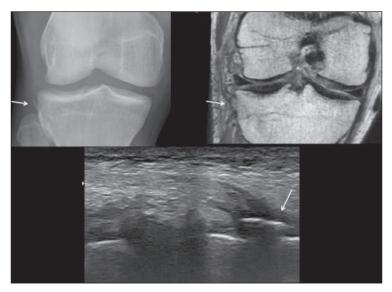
Example of ALL tear by distal avulsion (arrow). The standard radiography shows a Segond fracture. The 3D T2-weighted MRI and ultrasound show the pathological thickening of the ALL and its bony avulsion at the distal enthesis. Note the anterior cruciate ligament tear on the MRI (asterisk). Thanks to Marie Faruch.
